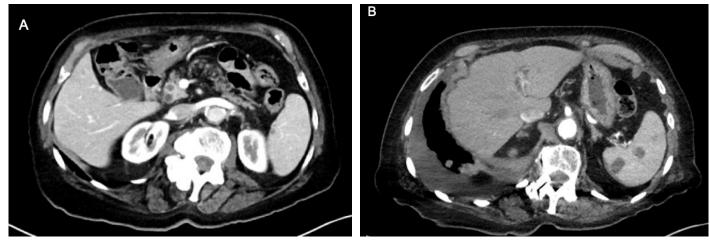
January 2020 CT chest, abdomen, and pelvis with contrast. Axial view. Stable pulmonary nodules, multiple lesions in the spleen, and multiple sclerotic and lytic lesions are present in lumbar spine, bony pelvis, and left proximal femur. Stable small 12 cm pancreatic head hypodense mass.
